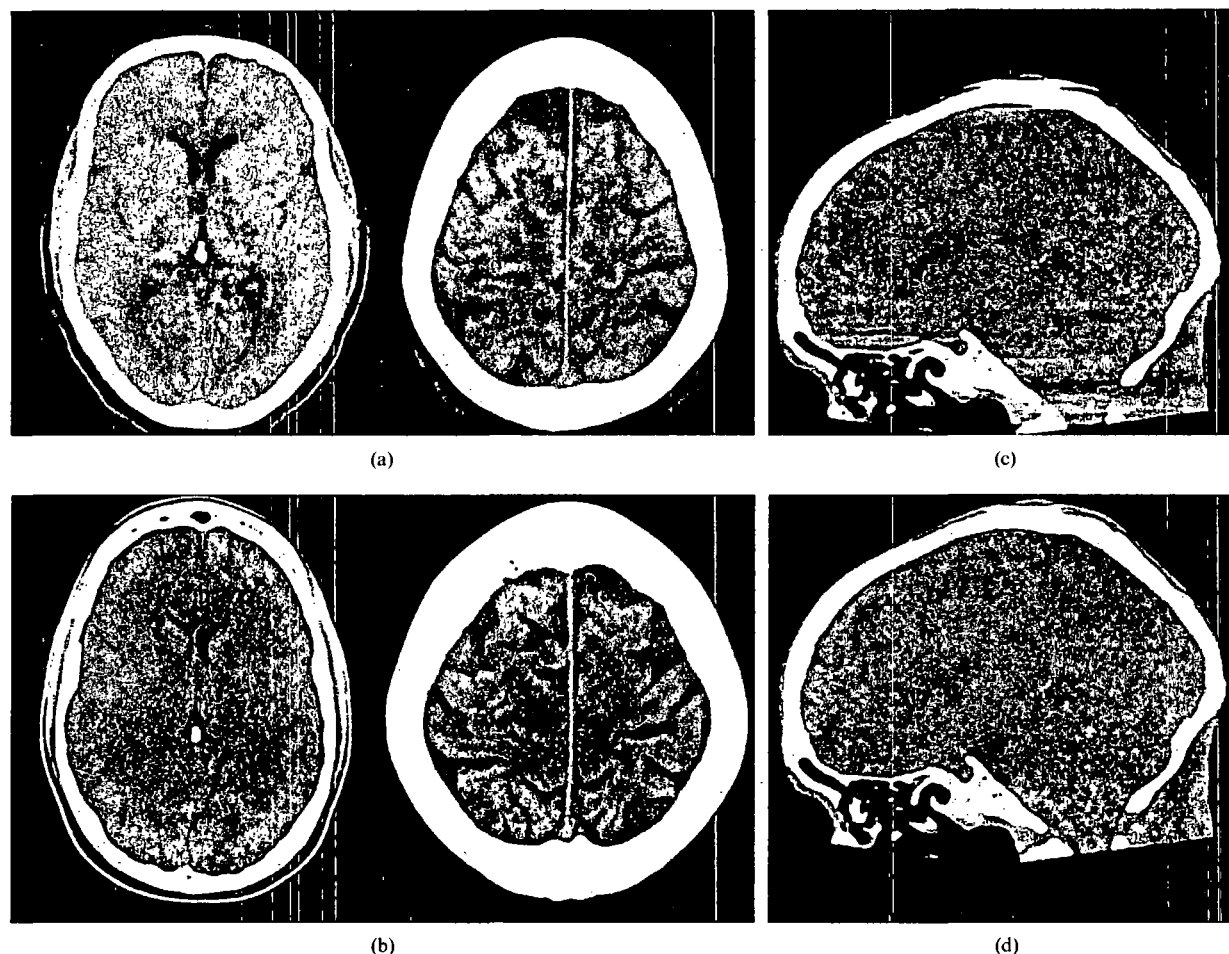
Comparison of unenhanced CT scans of the head (8 mm axial sections) at the level of the basal ganglia and the high semioval centre. (a) Single rotation 320-slice CT. (b) Incremental 64-slice CT. The image quality of the 64-slice CT concerning the differentiation of grey and white matter is seen to be superior. (c, d) Sagittally reformatted 0.5 mm section of single-rotation 320-slice CT (c) without and (d) with cone beam artefact correction algorithm. Note the substantially reduced artefacts in the posterior fossa.
